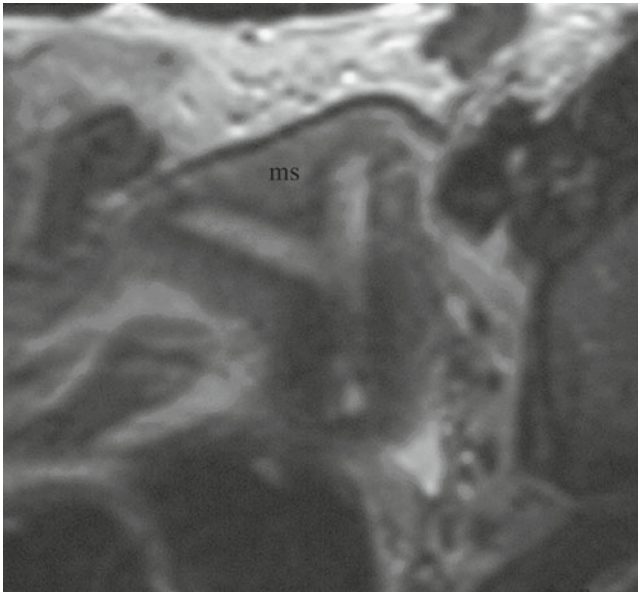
Septate uterus. This is best appreciated on oblique coronal T2-weighted image through the uterine canal demonstrating myometrial septum (ms). Reproduced with permission from Magen A, Veniero JC. In: Hurd WW, Falcone T, eds. *Clinical reproductive medicine and surgery*. St. Louis, MO: Mosby/Elsevier; 2007. (Fig. 31.9 from 1st ed)
